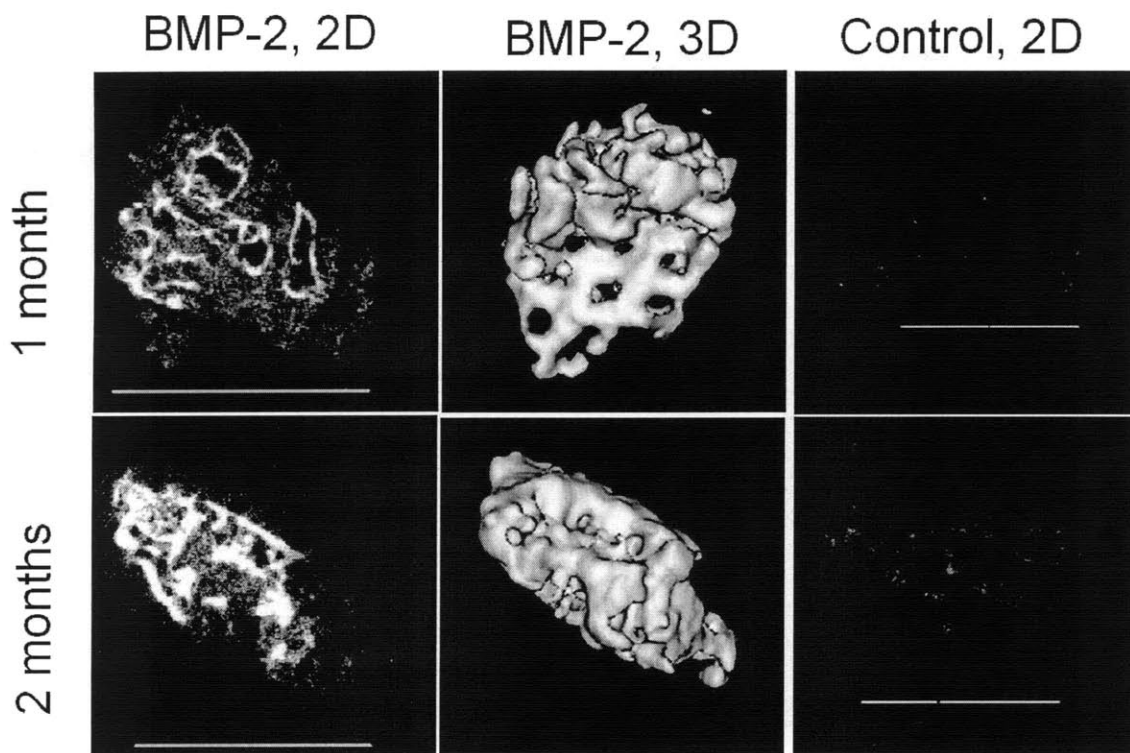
Micro computed tomography images of explanted in vivo samples at one and two months. Two dimensional slices through BMP-2 active samples show bone thickening and more intense signal suggesting higher bone mineral density with increasing time. Three dimensional images show the concentric positioning of the bone around the 3DP struts. Controls thresholded to the same values show very little
